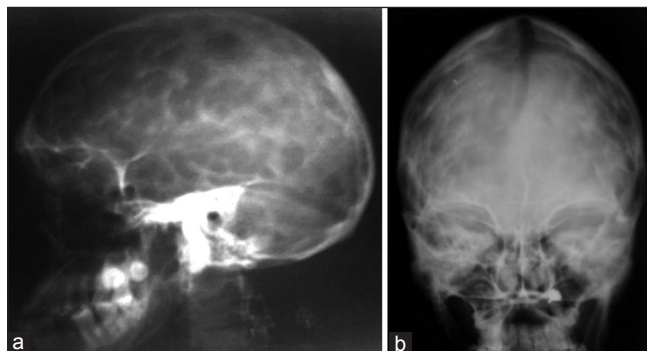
X-ray of the skull lateral (a) and frontal (b) view shows prominent convolutional markings and closure of cranial sutures. The frontal paranasal sinuses are hypoplastic
